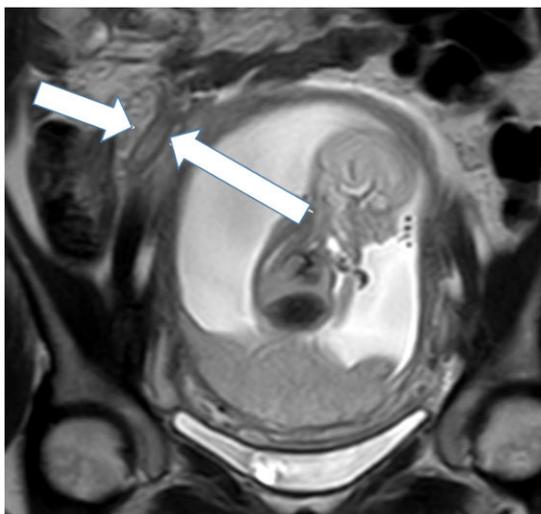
MRI image of uncomplicated acute appendicitis in a pregnant patient (thick arrows: appendix).
